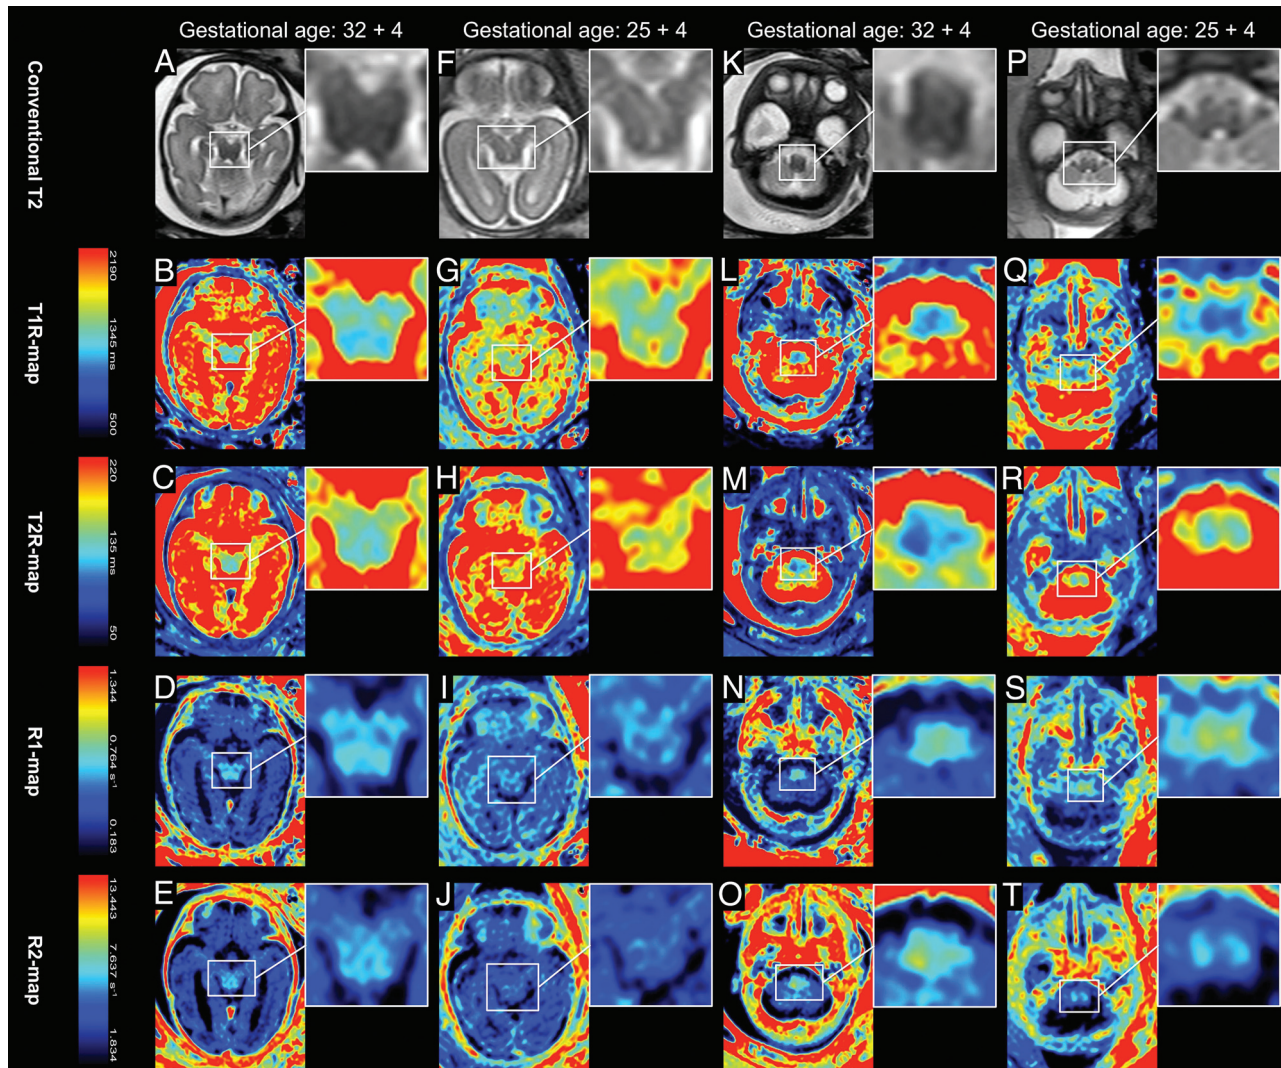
Presentation of conventionally acquired T2-weighted MR imaging contrasts (A, F, K, P) and quantitative MR imaging maps based on T1R (B, G, L, Q), T2R (C, H, M, R), R1 (D, I, N, S), and R2 (E, J, O, T). The color-coding, according to the T1-/T2-relaxation parameters, is indicated by the colored bars. The first (A, B, C, D, E) and the third columns (K, L, M, N, O) show MR imaging data from a fetus imaged at 32 + 4 weeks' GA. The second (F, G, H, I, J) and the fourth columns (P, Q, R, S, T) show MR imaging data from a fetus imaged at 25 + 4 weeks' GA. Brain myelination is indicated by a shortening of T1R/T2R (blue color-coding) and a prolongation of R1/R2 (yellow/orange color-coding). The color-coding of T1-relaxation parameters shows a distinct myelination of the medulla oblongata (L, N) and the midbrain tegmentum/tectum (B, D) at 32 + 4 weeks' GA. At 25 + 4 weeks' GA, only the medulla oblongata shows remarkable myelination (Q, S). The color-coding of T2-relaxation parameters indicates myelination of the medulla oblongata (M, O) at 32 + 4 weeks' GA. Beginning T2R-shortening and R2-prolongation are visible in the medulla oblongata (R, T) at 25 + 4 weeks' GA and in the midbrain tegmentum/tectum (C, E) at 32 + 4 weeks' GA.
